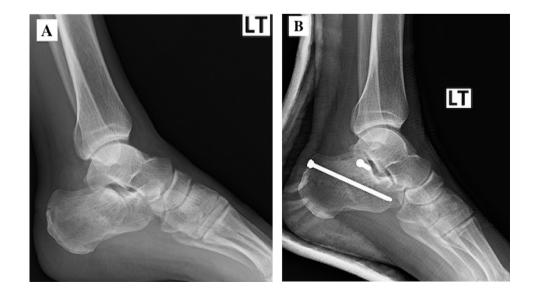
Postoperative lateral radiograph demonstrating reduction and healing of fracture with screws-only fixation at 6 months
